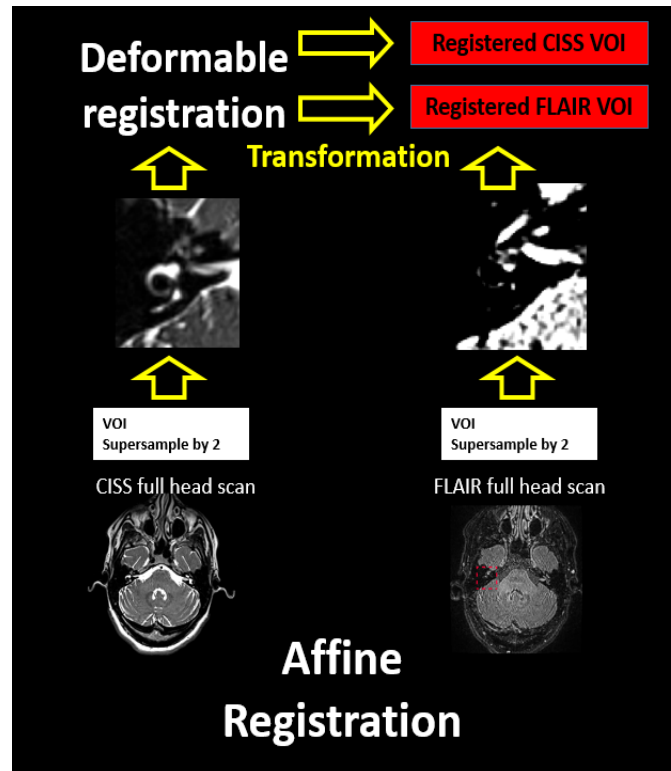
Pre-processing of the dataset’s CISS and FLAIR sequences for the EL/PL extraction using a sequential multi-modal segmentation
